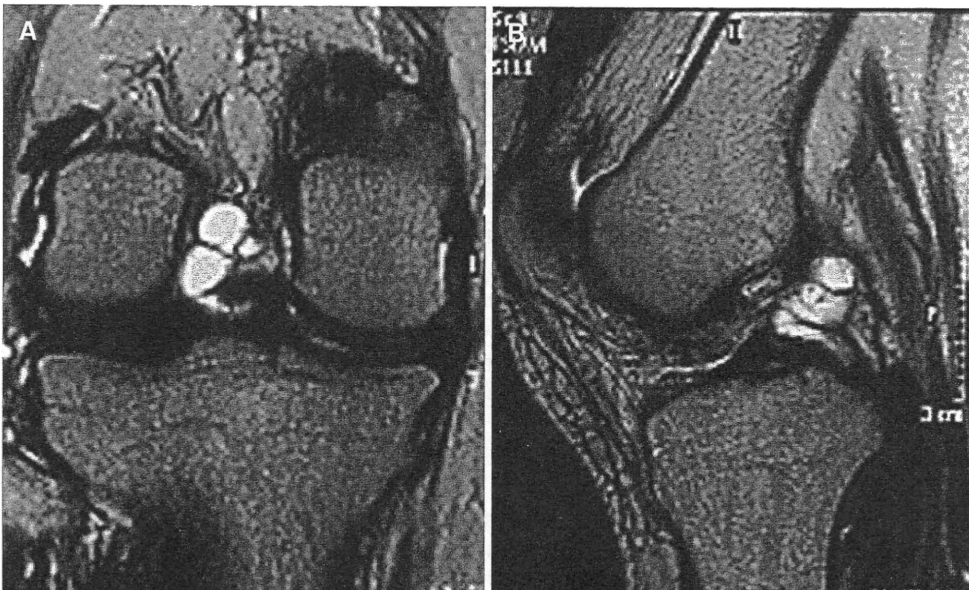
Preoperative T2-weighted magnetic resonance imaging in the coronal plane (A) and sagittal plane (B) shows a multilobulated cystic mass posterior to the posterior cruciate ligament
